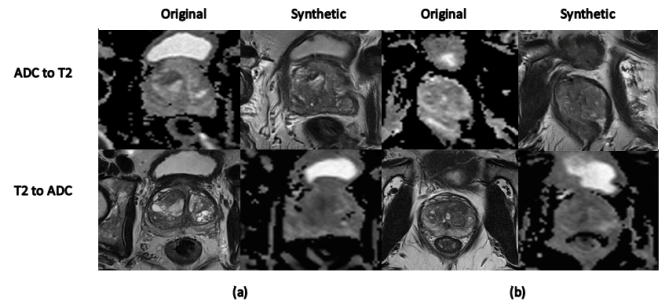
Preliminary CycleGAN Results: a) The four images in the left 2x2 block correspond to patient a. The first column has an ADC scan and its paired T2-weighted scan, while the second column has the corresponding generated images from the CycleGAN network. The right 2x2 block has the same representation for patient b.
